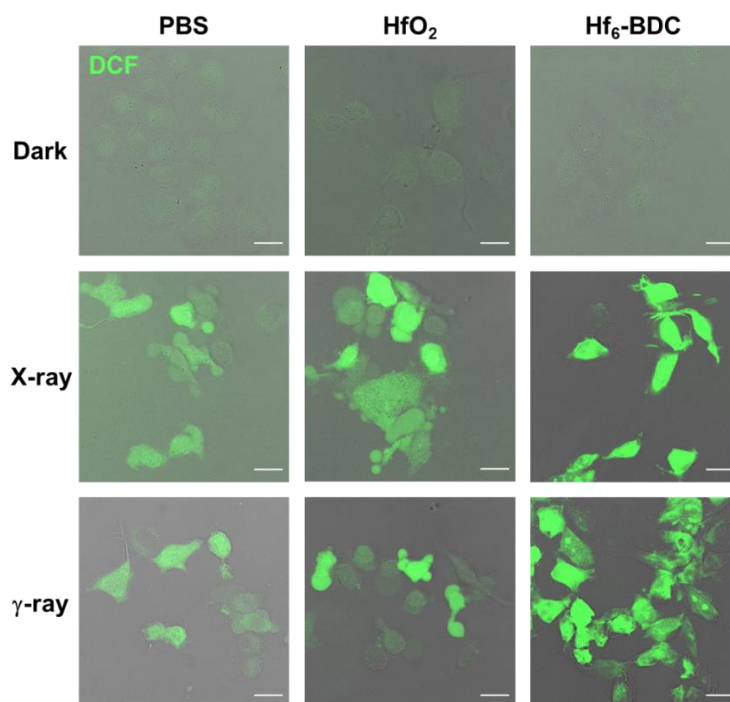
Confocal imaging of DCFH-DA assay showing total ROS detection in CT26 cells treated with PBS, HfO₂ or Hf₆-BDC and irradiated with X-ray or γ -ray at a dose of 4 Gy.
